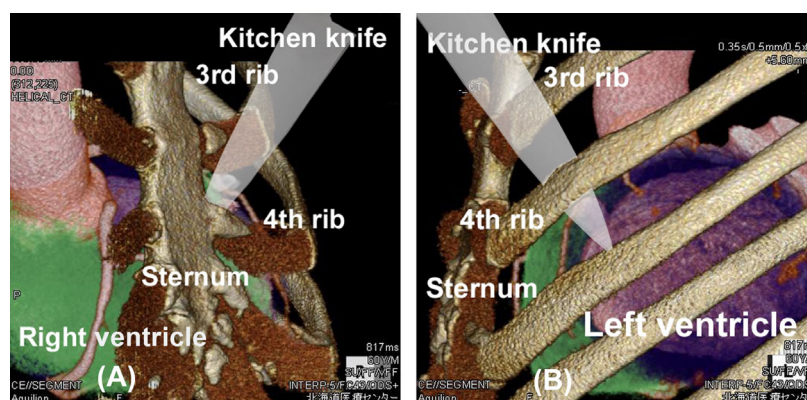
Entry pathway of a kitchen knife (indicated by a white triangle) into the chest of a 60-year-old man is estimated from the position of ventricular septal perforation, as shown by computed tomography. The patient grabbed the knife with the right hand and stabbed himself in the third intercostal space.
